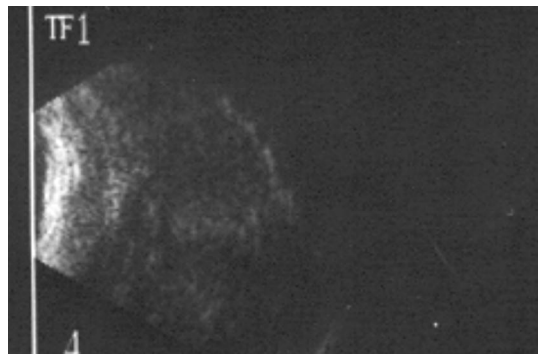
B scan ultrasound of a porous polyethylene sphere 90 days after surgery
